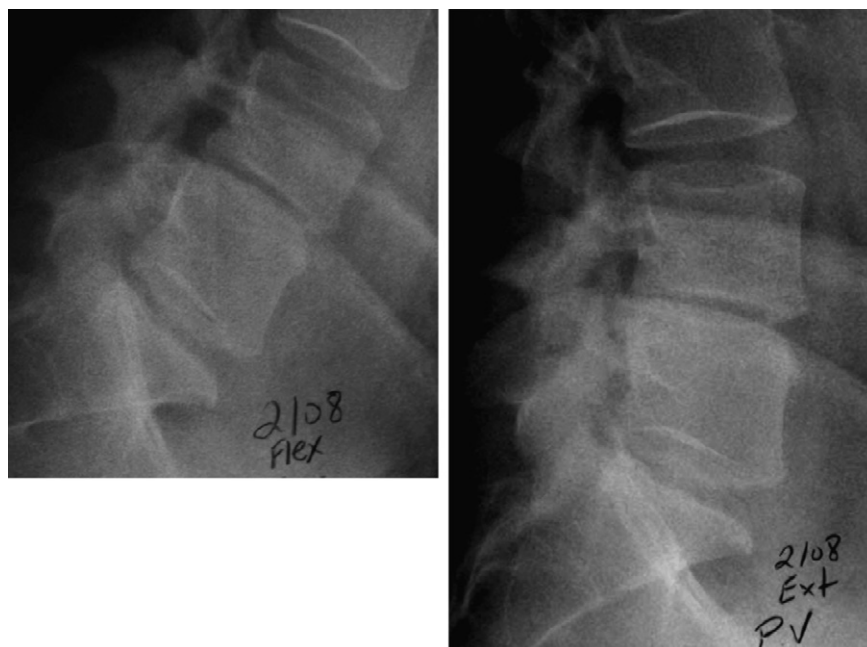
(Left) Preoperative lateral flexion and (Right) extension radiographs showing decreased disc space height at L4–L5.
